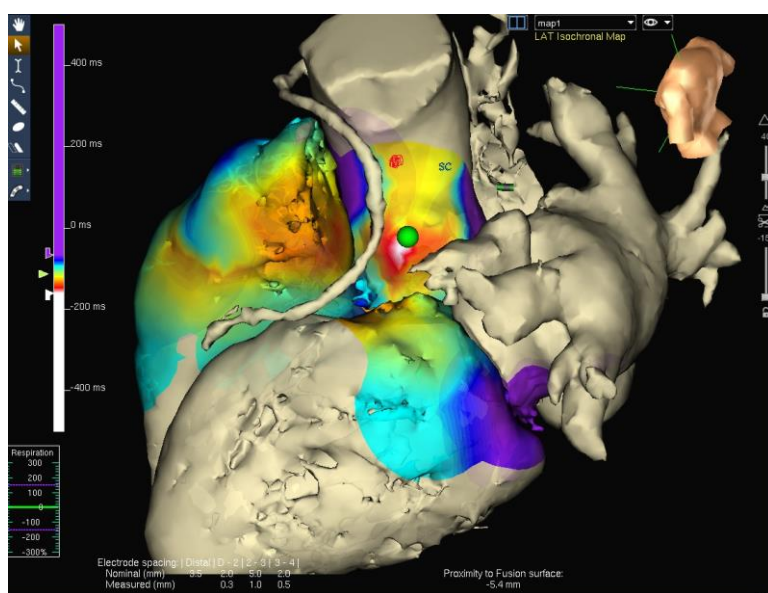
The use of electroanatomical mapping system (in this case NavX) and 3D CT image integration. The arrhythmia was originated in the aortic root marked with green dot (with courtesy of Barcelona Hospital Clinic, David Andreu, PhD).
